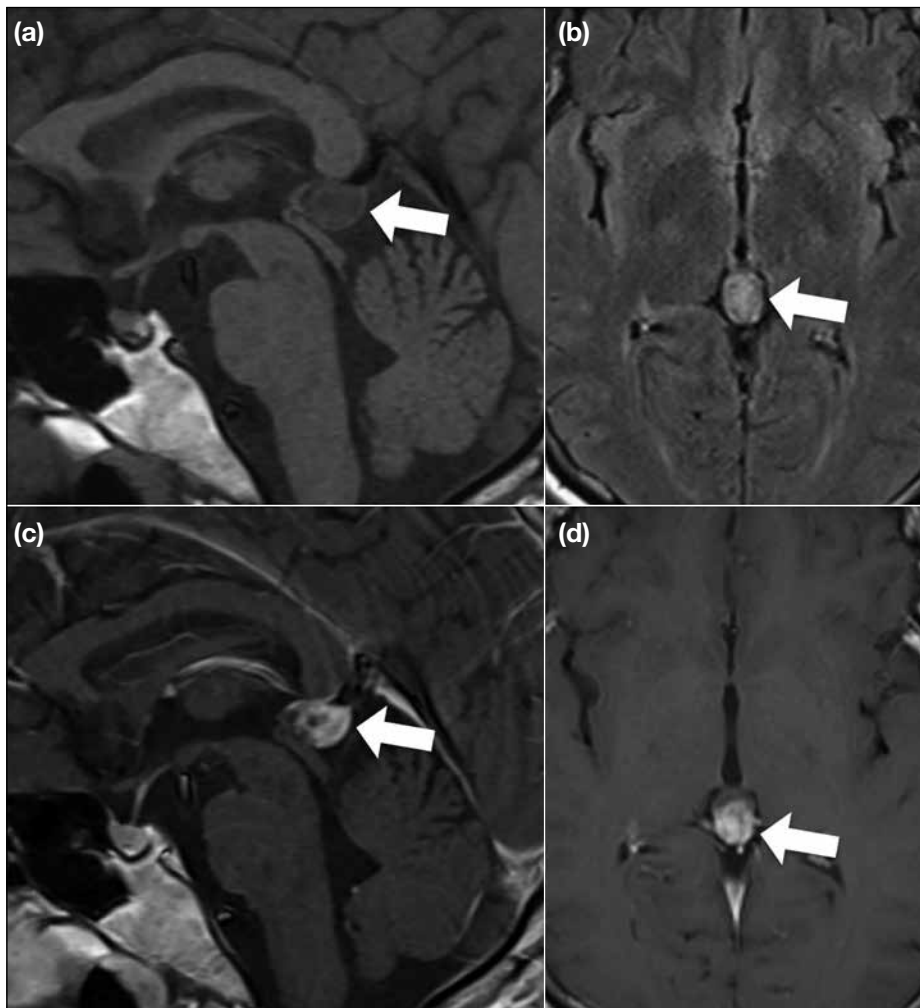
Pineal cyst. The case shows a pineal lesion (arrows) with heterogeneous hypointensity on sagittal T1-weighted image (a) and hyperintensity on axial T2-weighted fluid-attenuated inversion recovery image (b). About two-thirds of the lesion (arrows) enhances on sagittal (c) and axial (d) T1-weighted images.
